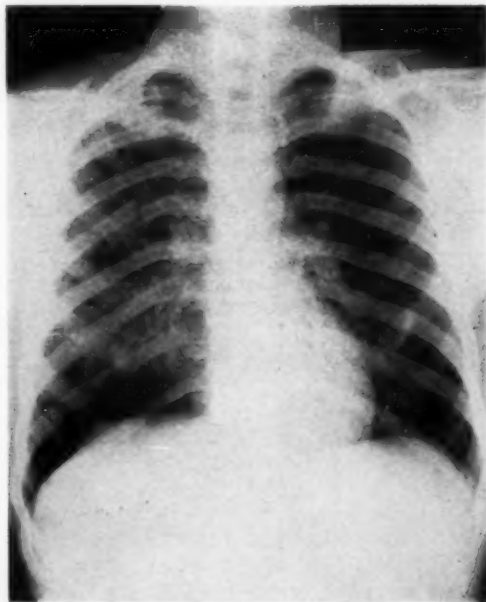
Primary pulmonary histiocytosis X or 2 years' duration (case 6). Typical roentgenogram of thorax with honeycombing and spontaneous pneumothoraces at the right base and left apex. A right parietal pleurectomy was done 1 year earlier, at the time of biopsy of lung tissue.
